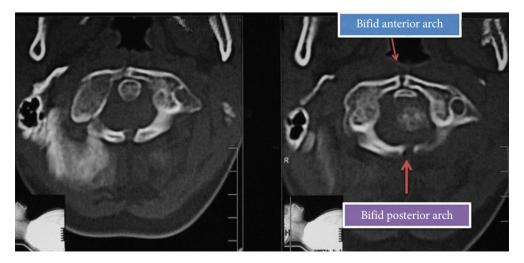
Axial computed tomography showing bifid anterior and posterior arches of atlas.
